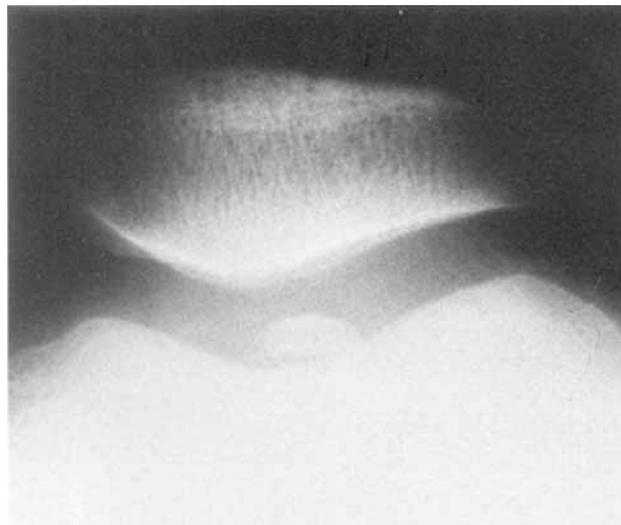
Horizontal radiograph of the ossicle
